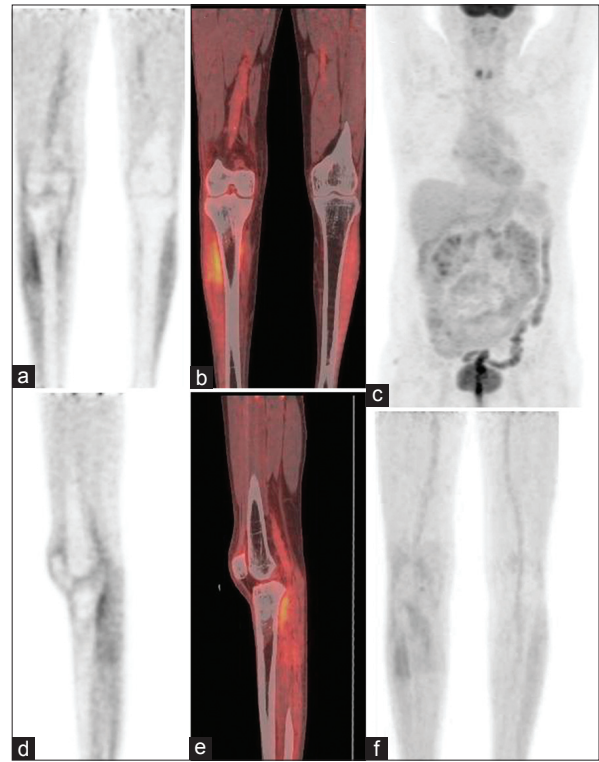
Posttreatment 18 fluoride-fluorodeoxyglucose positron emission tomography-computed tomography (PET-CT) showing complete resolution of metabolic activity in the proximal part of right tibia (coronal PET (a), fused coronal PET CT (b), sagittal PET (d), sagittal fused PET CT (e) and maximum intensity projection (MIP) lower limbs (f)). MIP of the whole body FDG PET (c) showing no abnormal lymph nodes elsewhere in the body. Minimal diffuse FDG uptake in the lower limbs muscles is likely related to local radiotherapy
